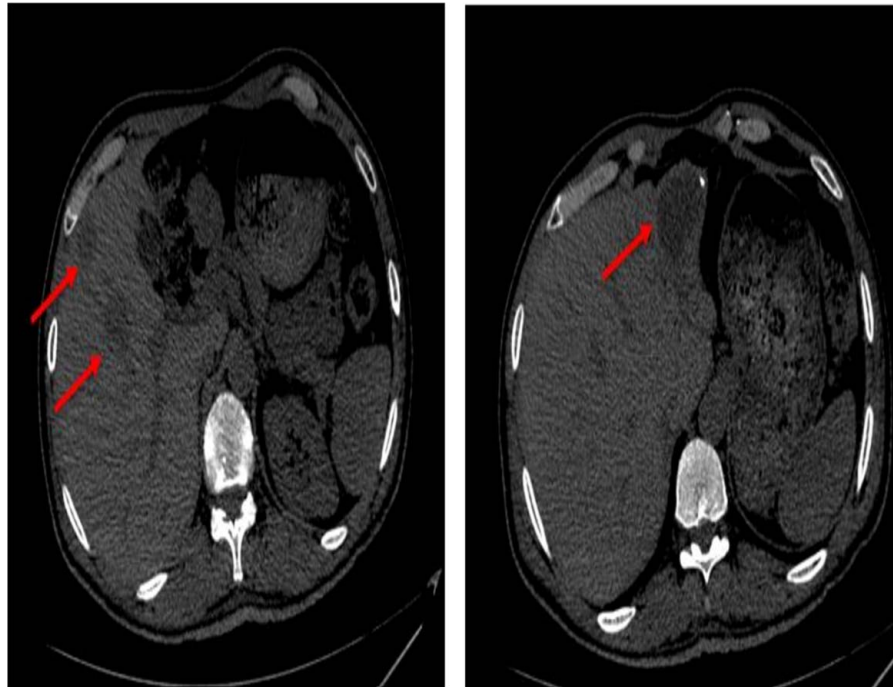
CT of the liver without IV contrast showed few well-defined hypodense hepatic lesions, the largest of about 4 × 3.5 cm showing few peripheral calcifications seen at the left lobe; suggestive of hydatid cysts. CT, computed tomography.
